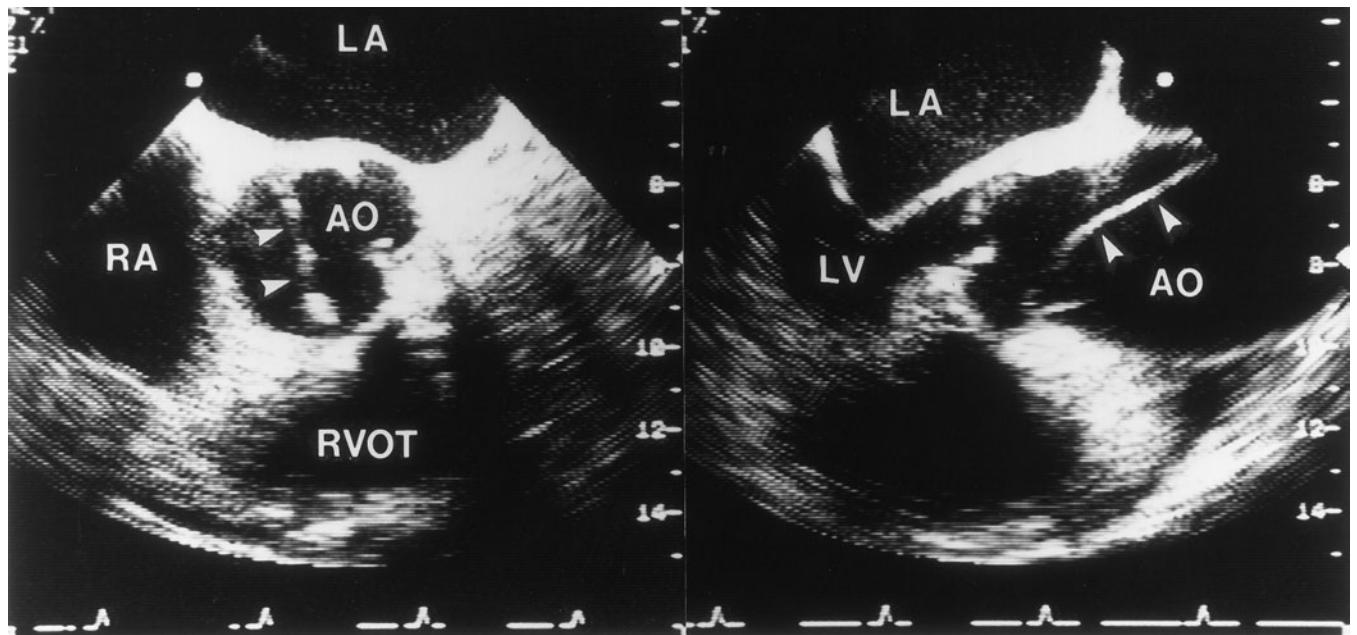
Transesophageal echocardiogram showing the dissection membrane (arrows) in the short (left panel) and long (right panel) views of a type A dissection.
